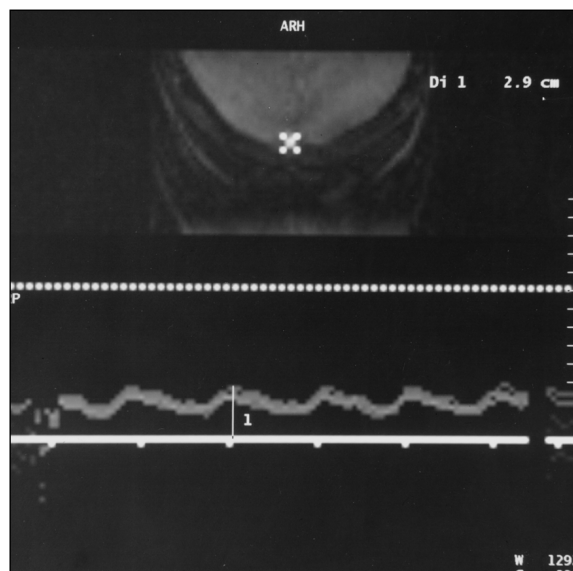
Normal duplex MR imaging of superior sagittal sinus in 34-year-old healthy female volunteer. Real-time duplex MR image (encoding velocity, 100 cm/sec) shows measurement of superior sagittal sinus (region of interest indicated by four white circles) during normal breathing. Note slow pulsatile flow with peak systolic velocity of 36.25 cm/sec. Craniocaudally directed flow is displayed above baseline.
